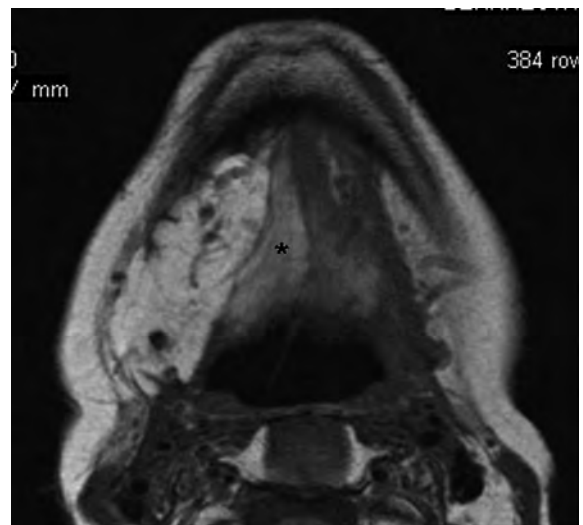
Axial MRI of 63-year-old male patient after resection of a squamous cell carcinoma with flap reconstruction on the *right* side (*a*). On the one hand, note the flow-voids of the arterial supply and the fatty transformation of the myocutaneous flap itself. And on the other hand, note the fatty transformation of the muscles (*star*) between the flap and the midline due to muscle denervation. The borders of the flap and of the anatomic structures are smooth, there is no evidence for recurrent tumor
